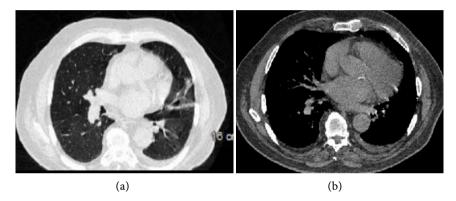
CT chest shows clearing of right lower lobe rounded opacity within 6 weeks (a & b).
